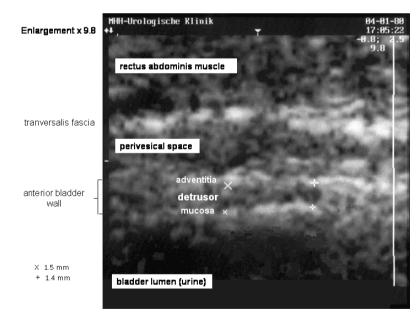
After enlargement of the digital ultrasound image (9.8x), the structures of the anterior bladder wall can be further analysed. Mucosa and adventitia appear hyperechogenic, the detrusor appears hypoechogenic. The distance between the two hyperechogenic lines represents the detrusor wall thickness (DWT) that can be measured with the integrated measuring function of the ultrasound device (in this example 1.4 and 1.5 mm).
